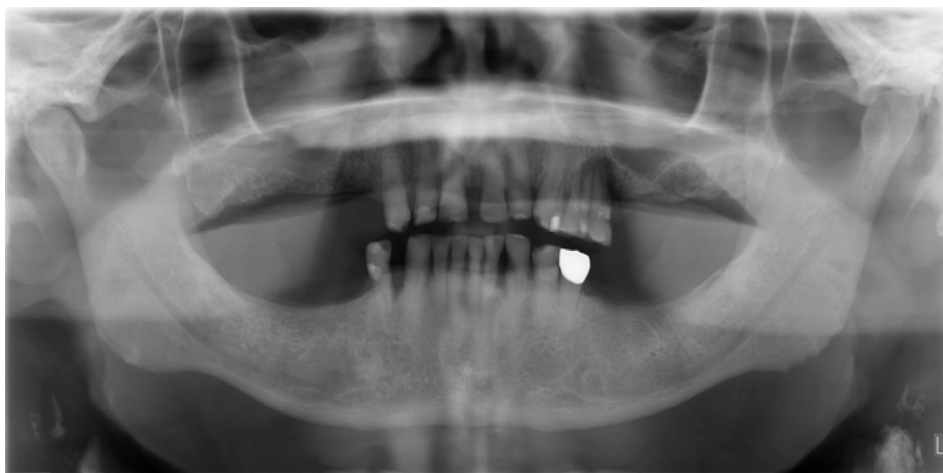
A panoramic radiograph shows bilateral linear soft tissue calcification in the cervical areas most consistent with calcified carotid atherosclerotic plaque. The inferior mandibular cortex represents the C2 Early stage of osteoporosis, showing semilunar defects with a normal cortical width by visual estimation.
